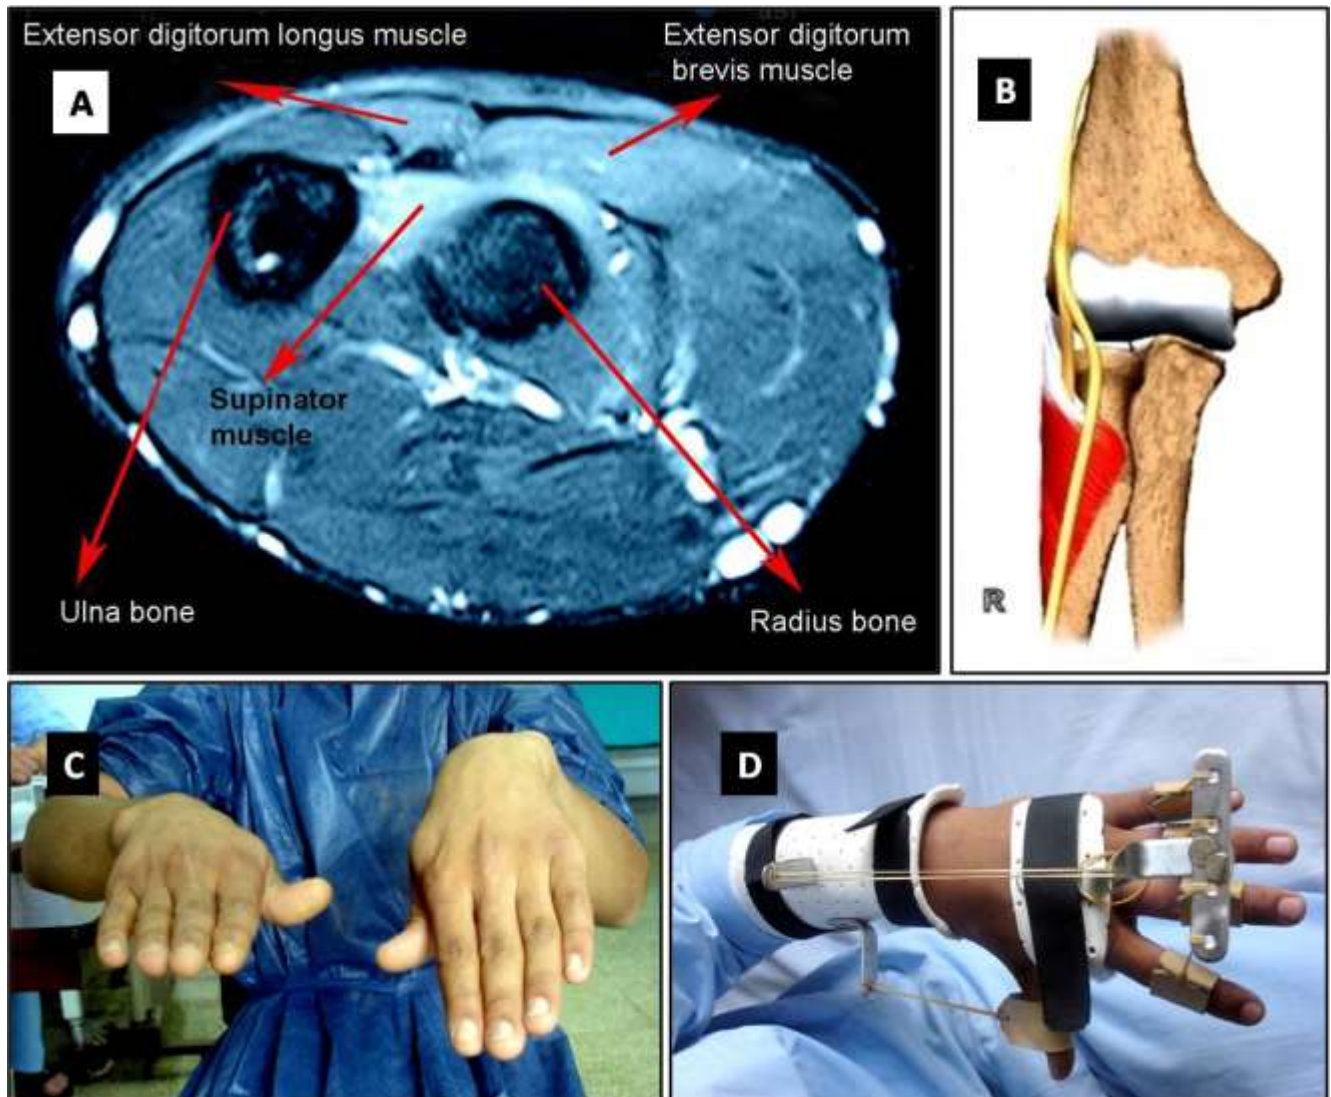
MRI image, course of the radial nerve and physical examination findings.
